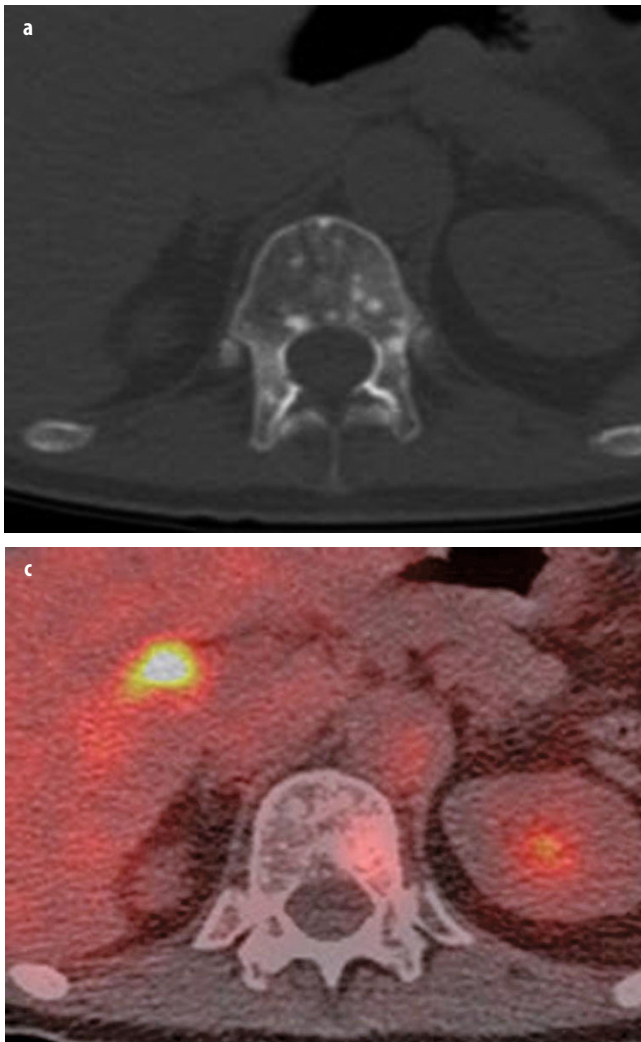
a-c. a Axial computed tomography (CT), b fused [^{18}F]-fluorodeoxyglucose (FDG) positron emission tomography computed tomography (PET/CT), and c fused [^{18}F]-fluoro-5 α -dihydrotestosterone (FDHT) PET/CT images demonstrate the biological diversity of bone metastases in patients with castration-resistant prostate cancer. Subtle ground-glass-appearing and miliary density lesion is present in the T12 vertebral body, with marked glycolytic activity but minimal androgen expression, as evidenced by uptake on FDG but not on FDHT PET
